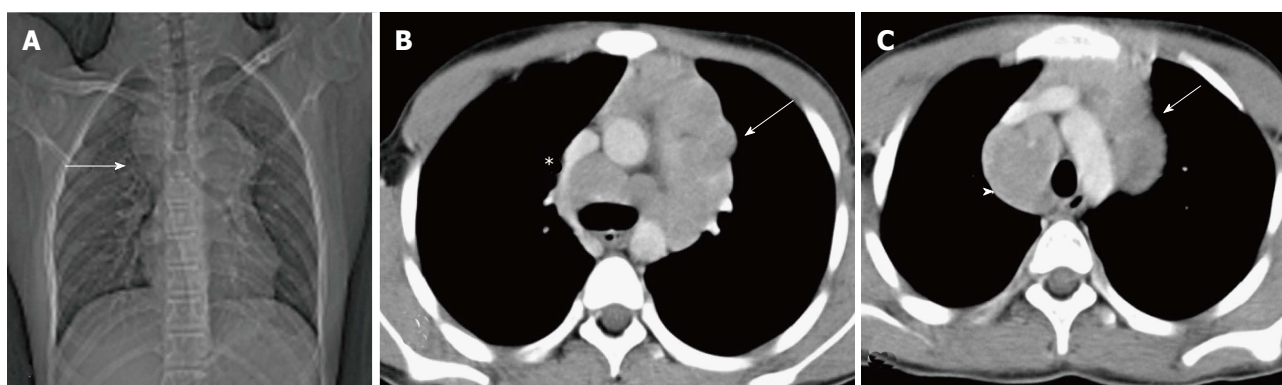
Hodgkin lymphoma in a 12-year-old boy presenting with fever and weight loss for 6 mo. CT scanogram (A) shows mediastinal widening (arrow) with lobulated contour. Axial CECT sections (B and C) reveal multiple, enlarged, homogenous lymph nodes in the region of the thymus (arrow in B and C) and paratracheal location (arrowhead in C). Note mild compression of SVC by this anterior mediastinal nodal mass (asterisk in B).
